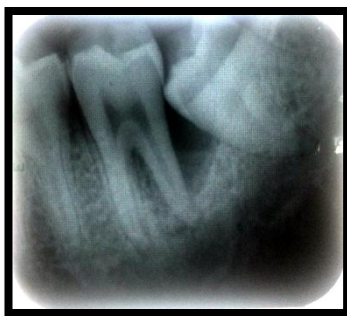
baseline radiograph (left mandibular second molar)
